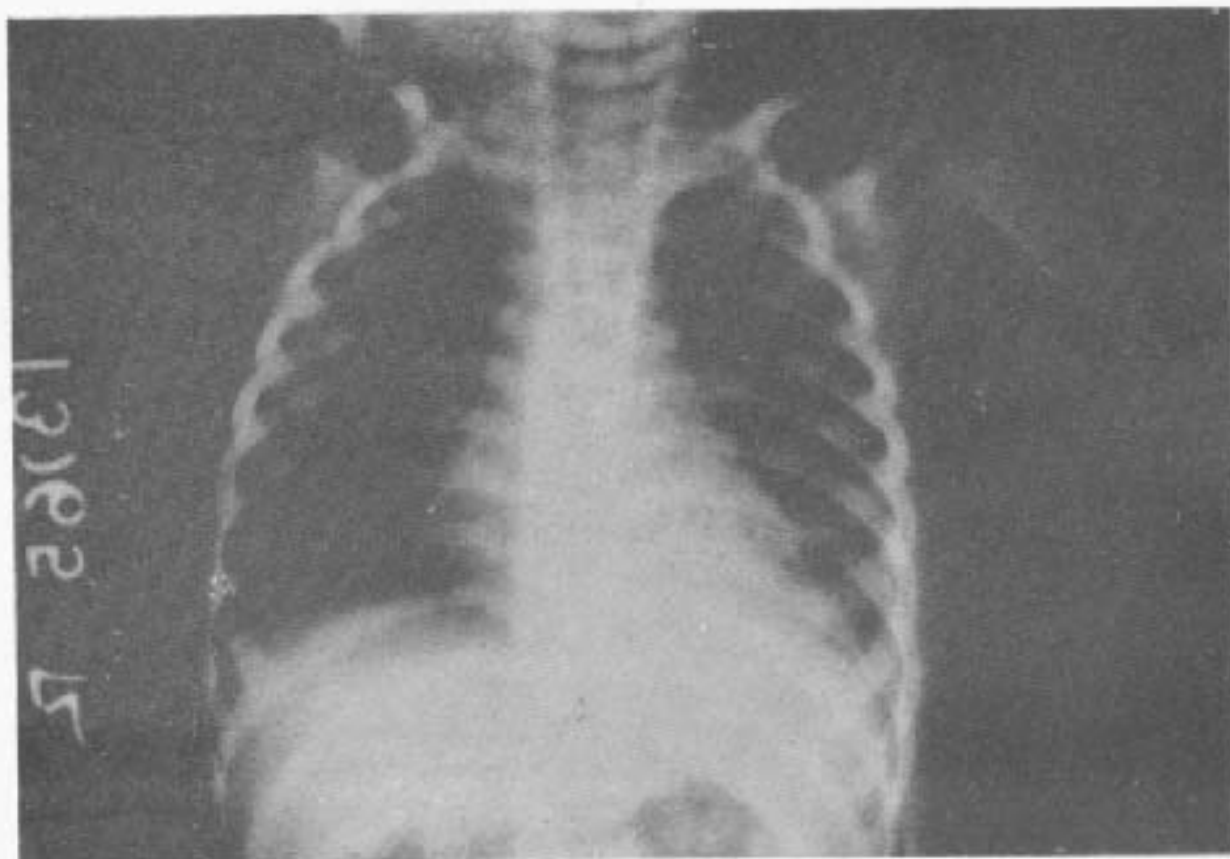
Plain X-ray chest showing collapsed left lower lobe.
